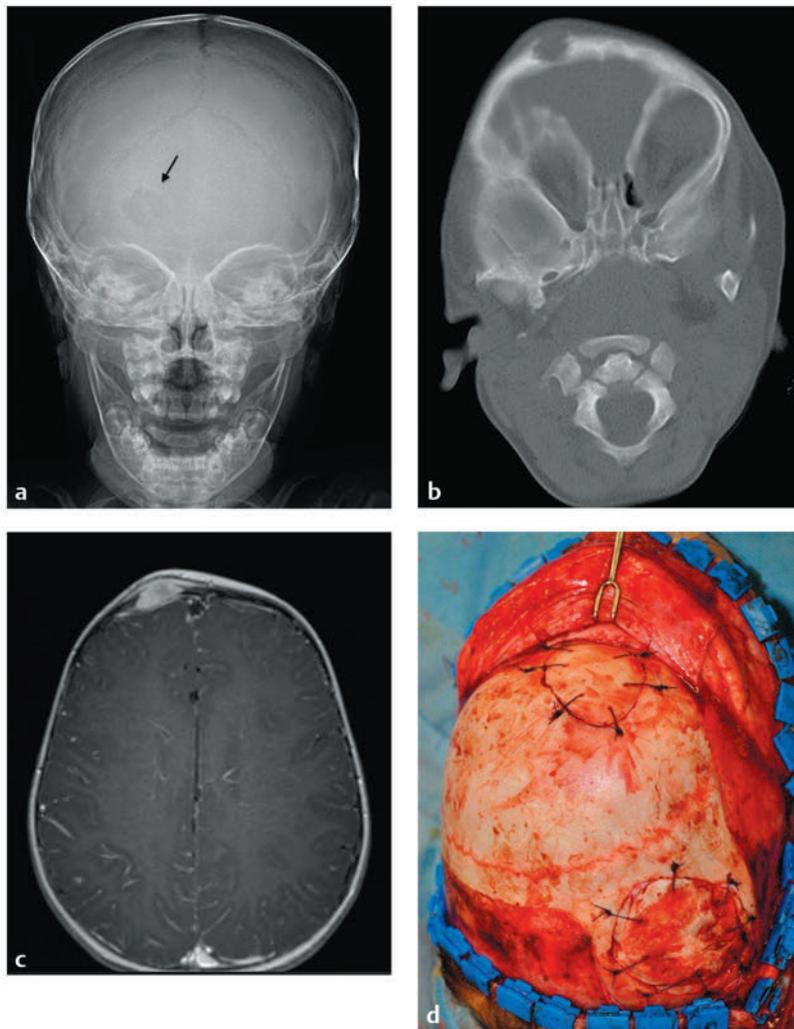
Langerhans cell histiocytosis. This 18-month-old girl presented with swelling over the left side of the forehead. (a) Skull X-ray shows a lytic lesion with irregular but not sclerotic margins. (b) Computed tomography with bone window. (c) Axial T1-weighted magnetic resonance imaging with contrast shows marked enhancement. The lesion failed to resolve over 6 months and was completely resected. Pathology was Langerhans cell histiocytosis. (d) At the time of resection, primary reconstruction with split-thickness autologous cranial bone was performed.
